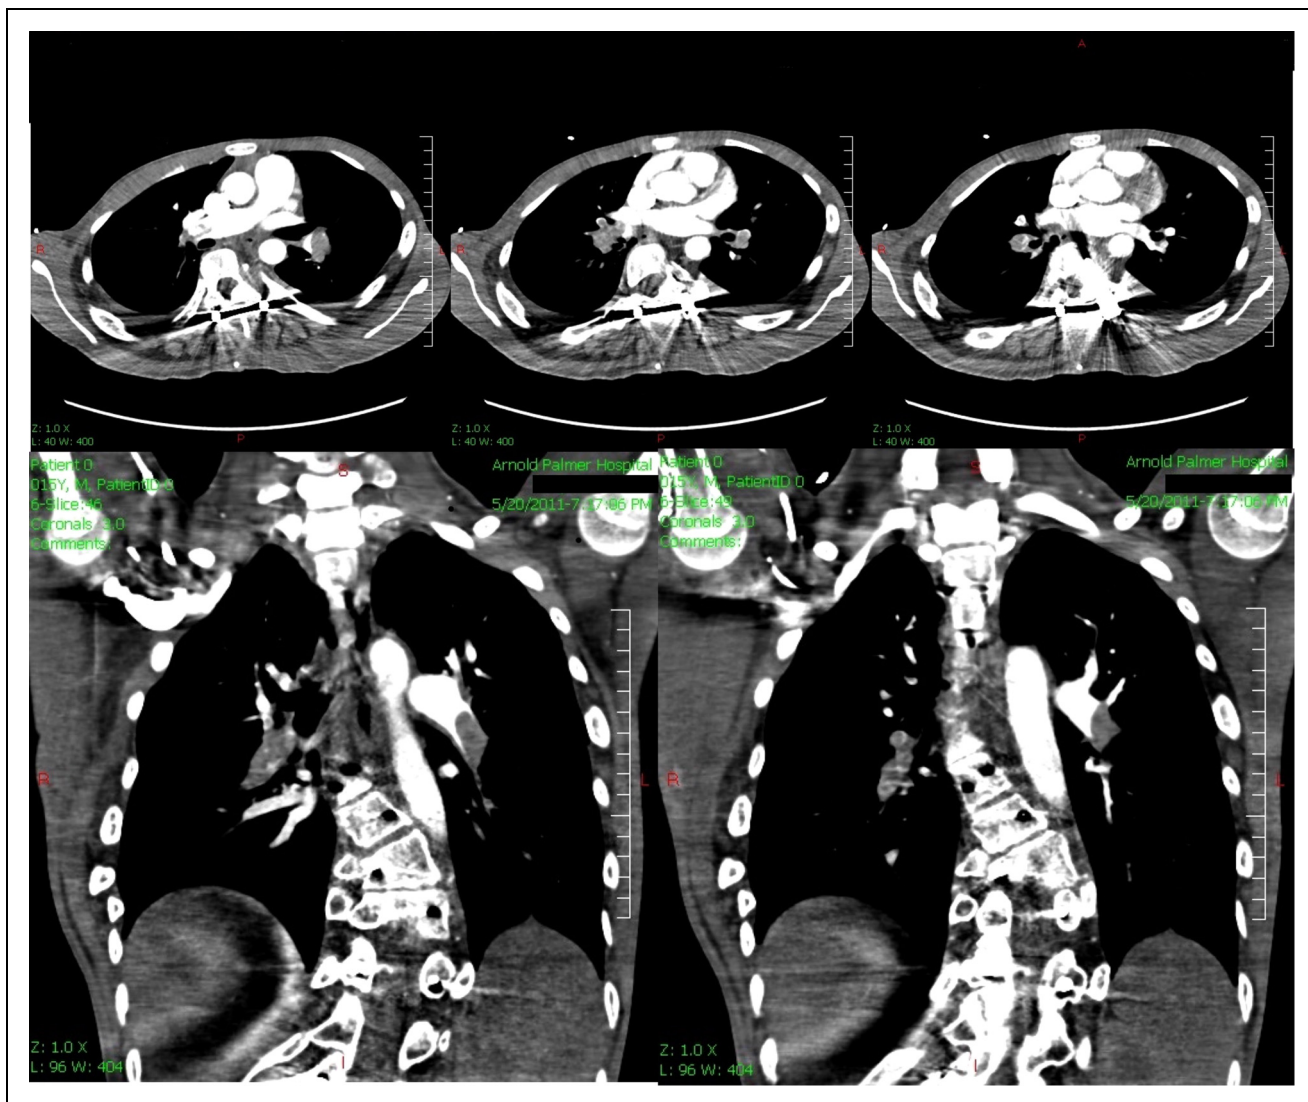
Transverse and vertical sections of CT Angiography represent filling defects in bilateral pulmonary arteries consistent with pulmonary embolism. The patient was suffering from extensive skeletal deformities and kyphoscoliosis the lipomatous overgrowth is prominent on both sides of the thorax.
